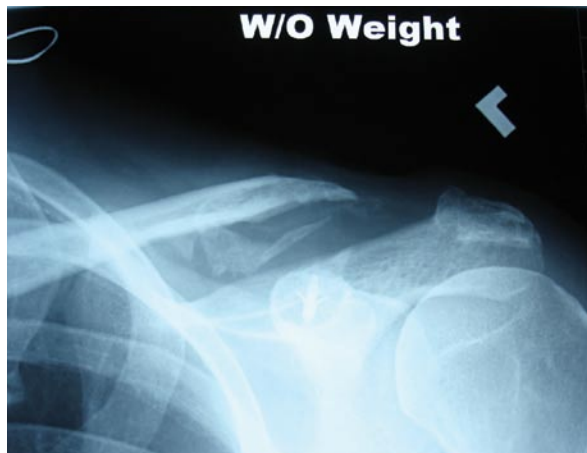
Twenty-five months after surgery, x-ray without weight shows mild increase in coracoclavicular distance and calcification of coracoclavicular ligaments.
